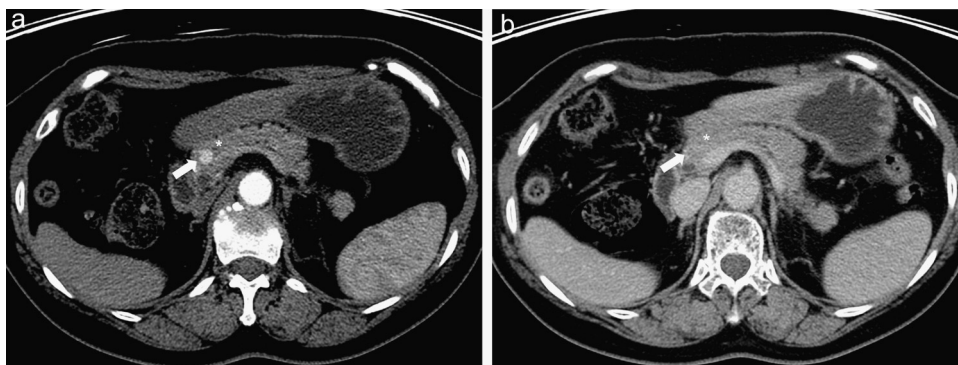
Axial dynamic CT scan in a 69-year-old female with pRCC.
